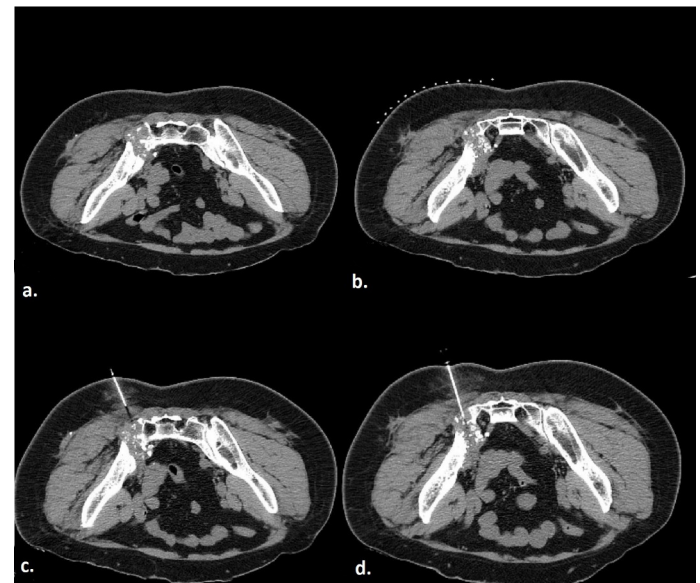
Procedural steps of CT-guided bone biopsy. (a) An expansile lytic-sclerotic (mixed-type) mass lesion involving the joint space and causing bone destruction in the right sacroiliac junction. (b) A guide marker placed at the appropriate level in the prone position to determine the skin entry point corresponding to the lesion location. (c) Reference image obtained after injecting 2% prilocaine hydrochloride into the skin, subcutaneous tissue, adjacent soft tissue-muscle planes and periosteum. (d) Biopsy needle insertion into the lesion and sample collection. The pathological diagnosis of the lesion was reported as chondrosarcoma.
